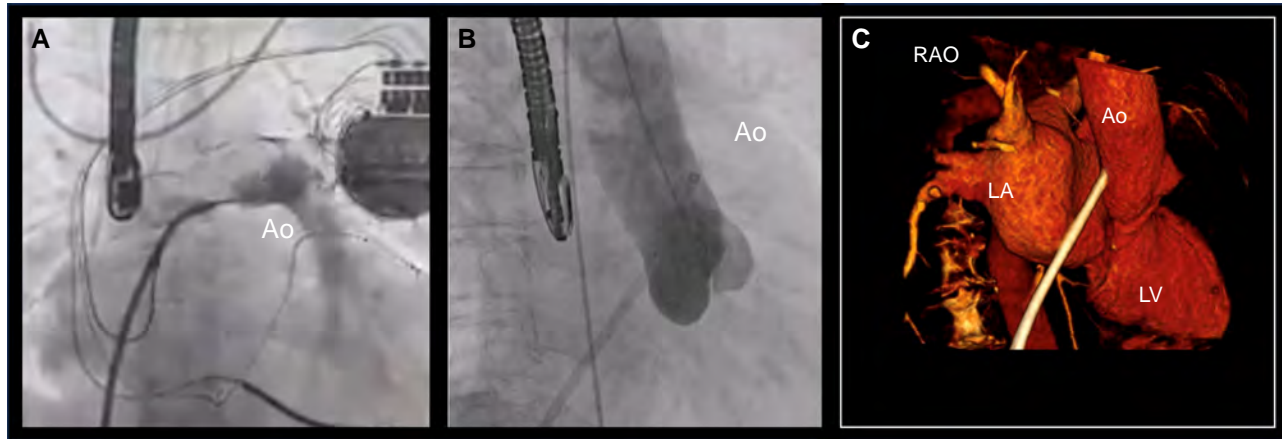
Inadvertent puncture of the aorta. Inadvertent puncture of the aorta during TSP attempt. A: Injection of dye through the transeptal needle shows contrast retained in the sinus of Valsalva. B: Contrast injection through the transeptal sheath confirms that the sheath has been advanced into the aortic root. C: 3D reconstruction of CT scan showing the transeptal sheath entering the aortic root.
